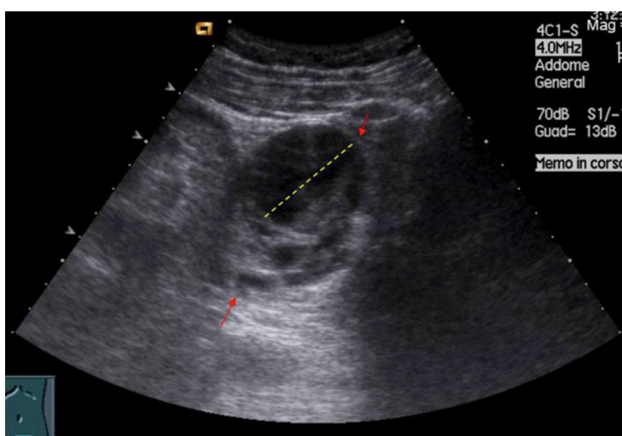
Ovarian cyst. Ultrasound image shows fine fibrinous strands within the cystic mass (yellow dotted line) in the right ovary, findings typical for hemorrhagic cyst
